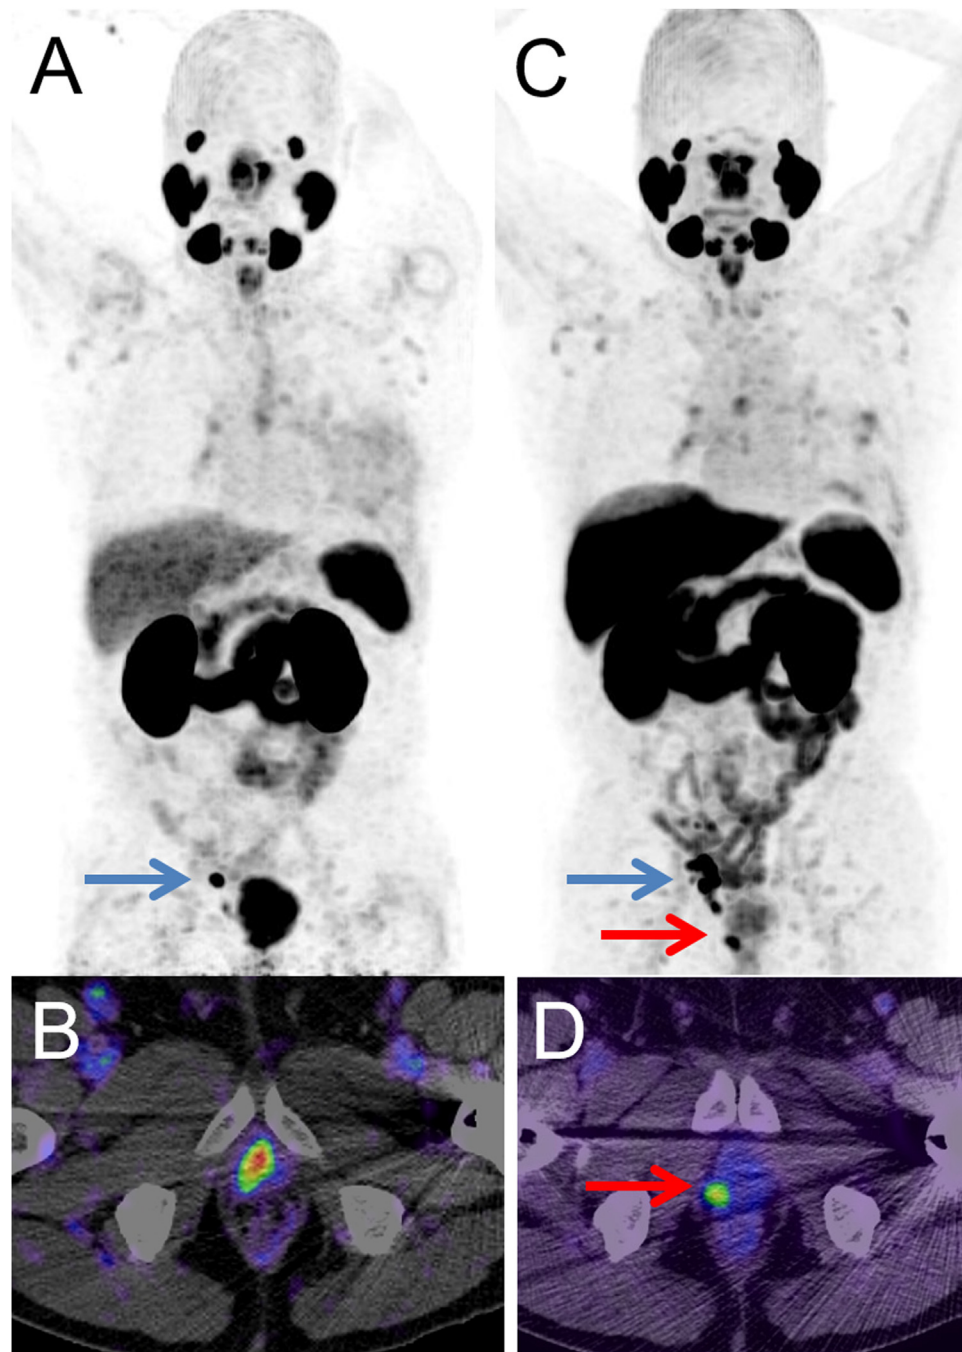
(A and B) Patient with BCR presenting with a PSMA PET–positive LN metastasis on ^{68}Ga -PSMA-11 PET (blue arrow) without evidence of a local recurrent tumour in the prostate bed due to urinary excretion of ^{68}Ga -PSMA-11 and subsequent tracer activity within the bladder. (C and D) A PSMA PET scan 3 mo later using ^{18}F -PSMA-1007 revealed, in addition to the LN metastasis (blue arrow), a local recurrence that was not obscured due to lack of urinary excretion of the tracer (red arrow). (A and C) PSMA PET maximum-intensity images and (B and D) axial PSMA PET/CT fusion images are shown. BCR = biochemical recurrence; LN = lymph node; PET = positron emission tomography; PSMA = prostate-specific membrane antigen.
